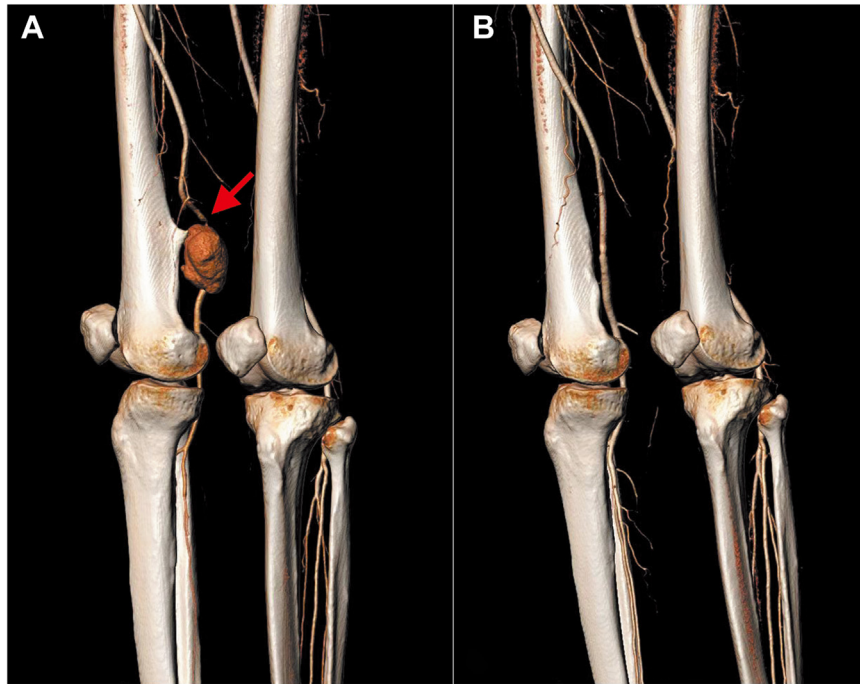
A, Three-dimensional computed tomography angiography (CTA) showing a bone spicule penetrating the pseudoaneurysm (red arrow). B, Three-dimensional CTA performed at 6 months postoperatively demonstrating excellent patency after revascularization and smooth bone surfaces.
